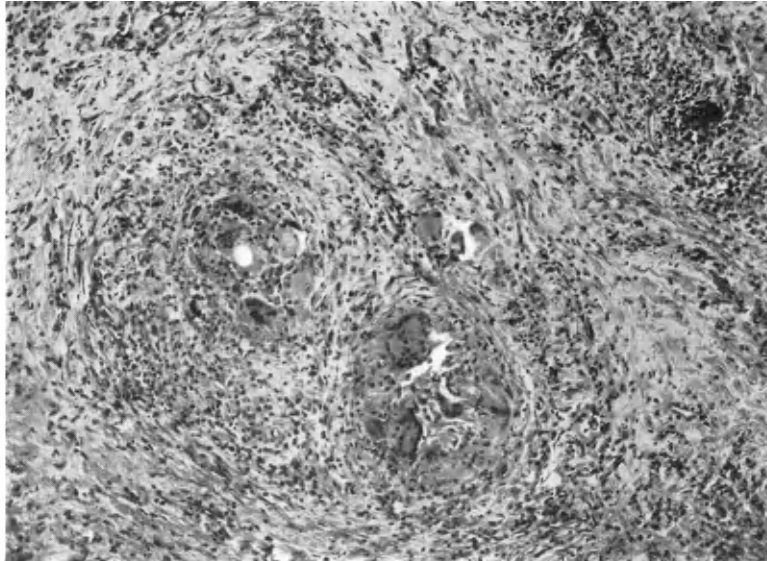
Biopsy of subacute or giant-cell thyroiditis. Prompt and complete resolution following X-ray treatment ( $\times 30$ ).
